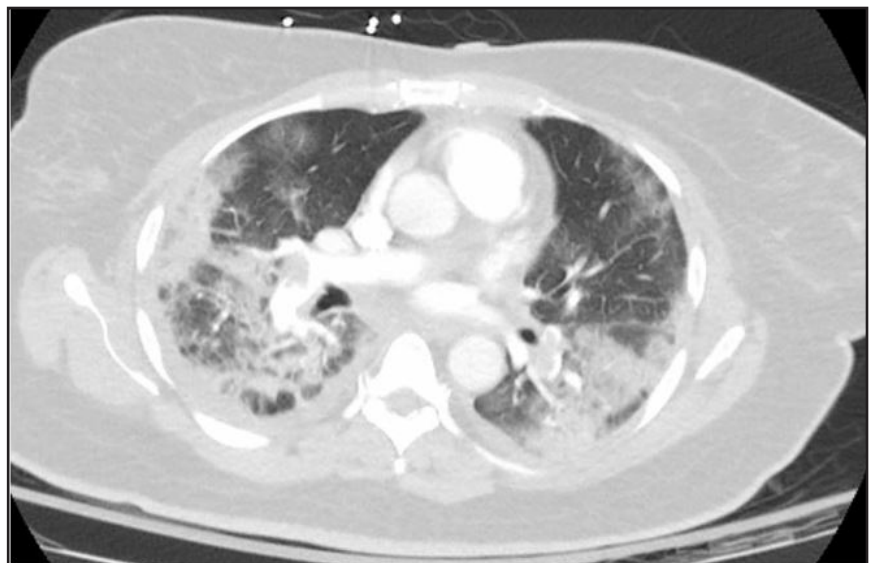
Chest CT scan showing bilateral large pulmonary emboli and extensive pulmonary infiltrates.
